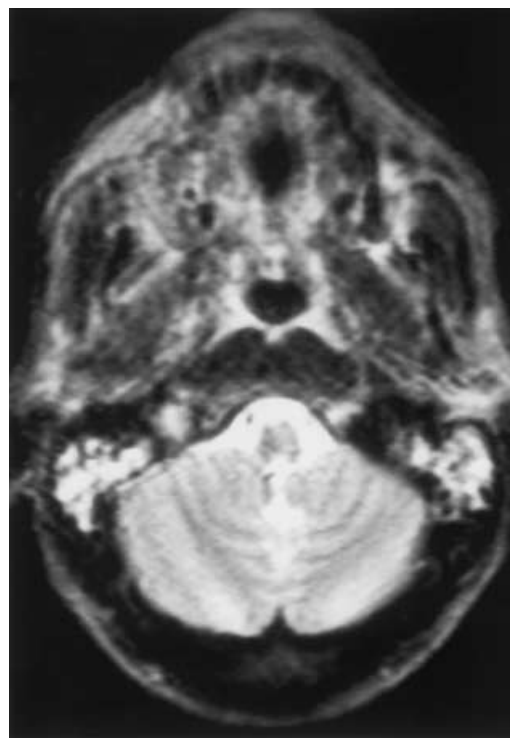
T2-weighted SE MRI (TR 3500 ms, TE 100 ms) 5 weeks after irradiation (70 Gy; squamous cell carcinoma of the hypopharynx; T4, N2, G2). Fluid accumulation in the mastoid cells with hyperintense signal intensity
